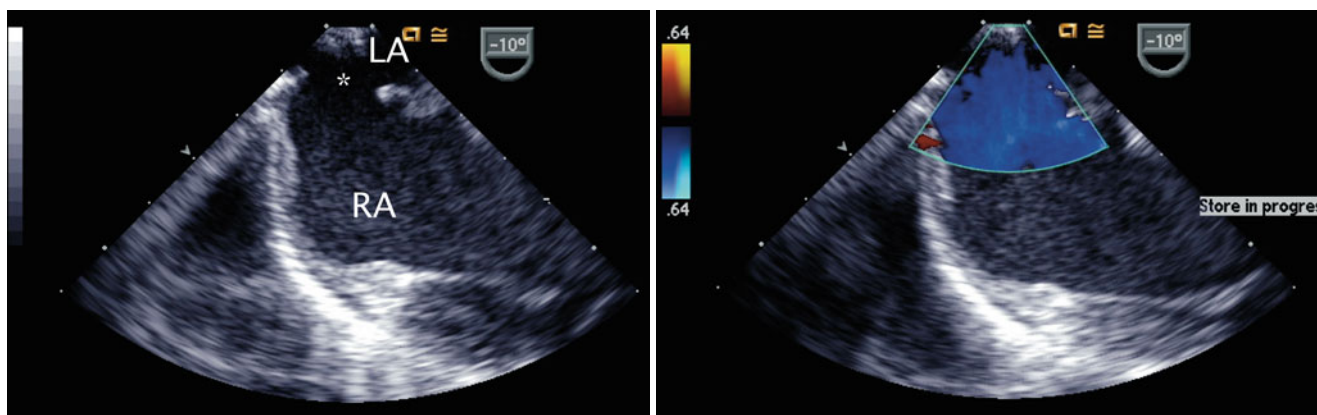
Left panel: Superior sinus venosus atrial septal defect (*asterisk*) as seen by withdrawal of the imaging probe above the level of the fossa ovalis from a mid esophageal position. Right panel: Color Doppler imaging demonstrating flow across the defect. LA left atrium, RA right atrium
